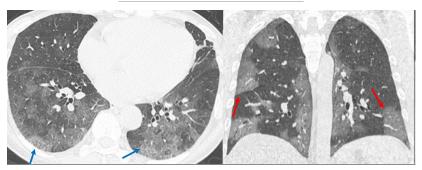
CT scan signs of Covid-19 - ground glass and crazy paving. Axial and coronal images show ill-defined perivascular ground glass opacities (red arrows) with axial and peripheral distribution and lower zone predominance. The crazy-paving pattern (blue arrows) occurs when there is associated septal thickening.
